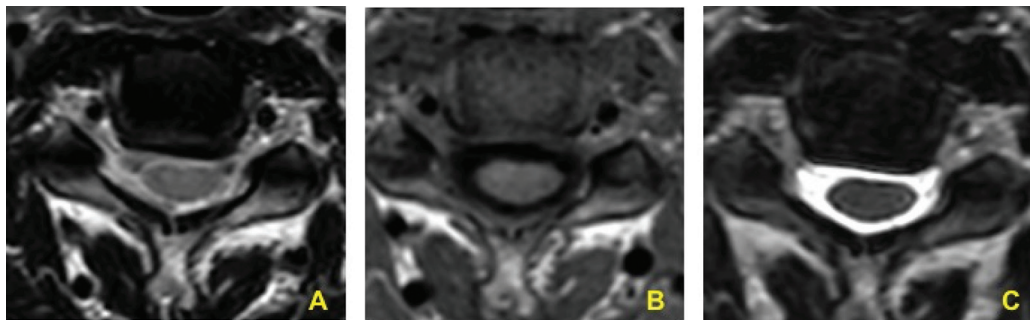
A 62-year-old female patient with cervical radiculopathy. MRI shows grade 1 cervical neural foramen stenosis (mild CNFS) bilaterally in (A) axial 2D T2W image, (B) axial 3D T1W image, and (C) axial 3D T2W image.
